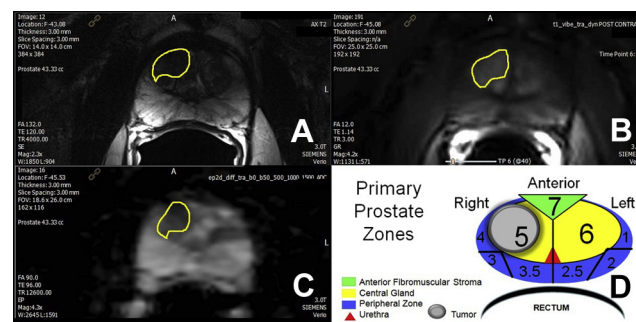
Prostate MP-MRI in 66-year-old male with PSA 5.6 ng/ml. *A*, T2-weighted axial image shows anterior right central lesion with charcoal sign (yellow outline). *B*, dynamic contrast enhanced with type 3 focal enhancement curve. *C*, ADC map with ADC value $487 \times 10^{-6} \times \text{mm}^2$ per second. *D*, primary prostate zones with MR tumor volume ($1.5 \times 1.4 \times 1.3 \text{ cm}^3$) and target core calculated volume (11 mm cancer) = 0.7 cm^3 .
